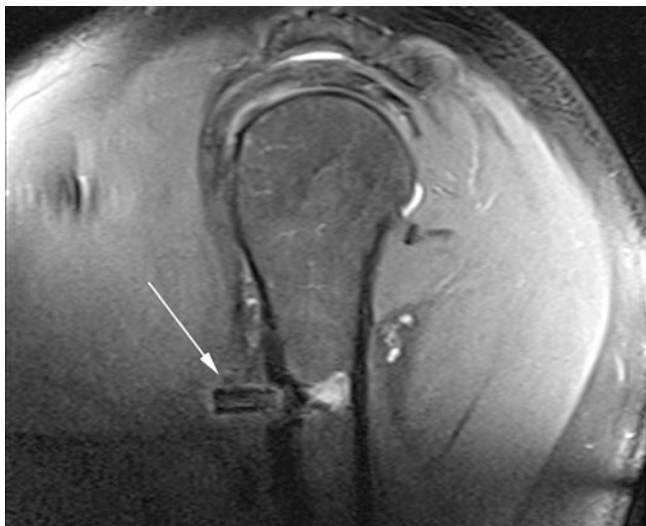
Sagittal oblique FS T1-weighted image from direct MR arthrogram demonstrated a dislodged interference screw (arrow) following biceps tenodesis
